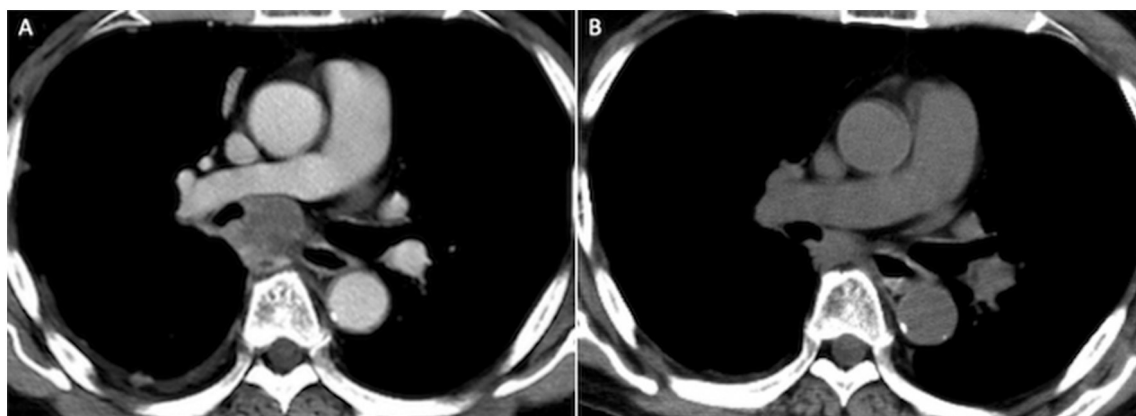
CT findings. (A) CT prior to pembrolizumab treatment. (B) CT 56 days after treatment showed tumor shrinking and partial response, based on the response evaluation criteria in solid tumors. CT, computed tomography.
